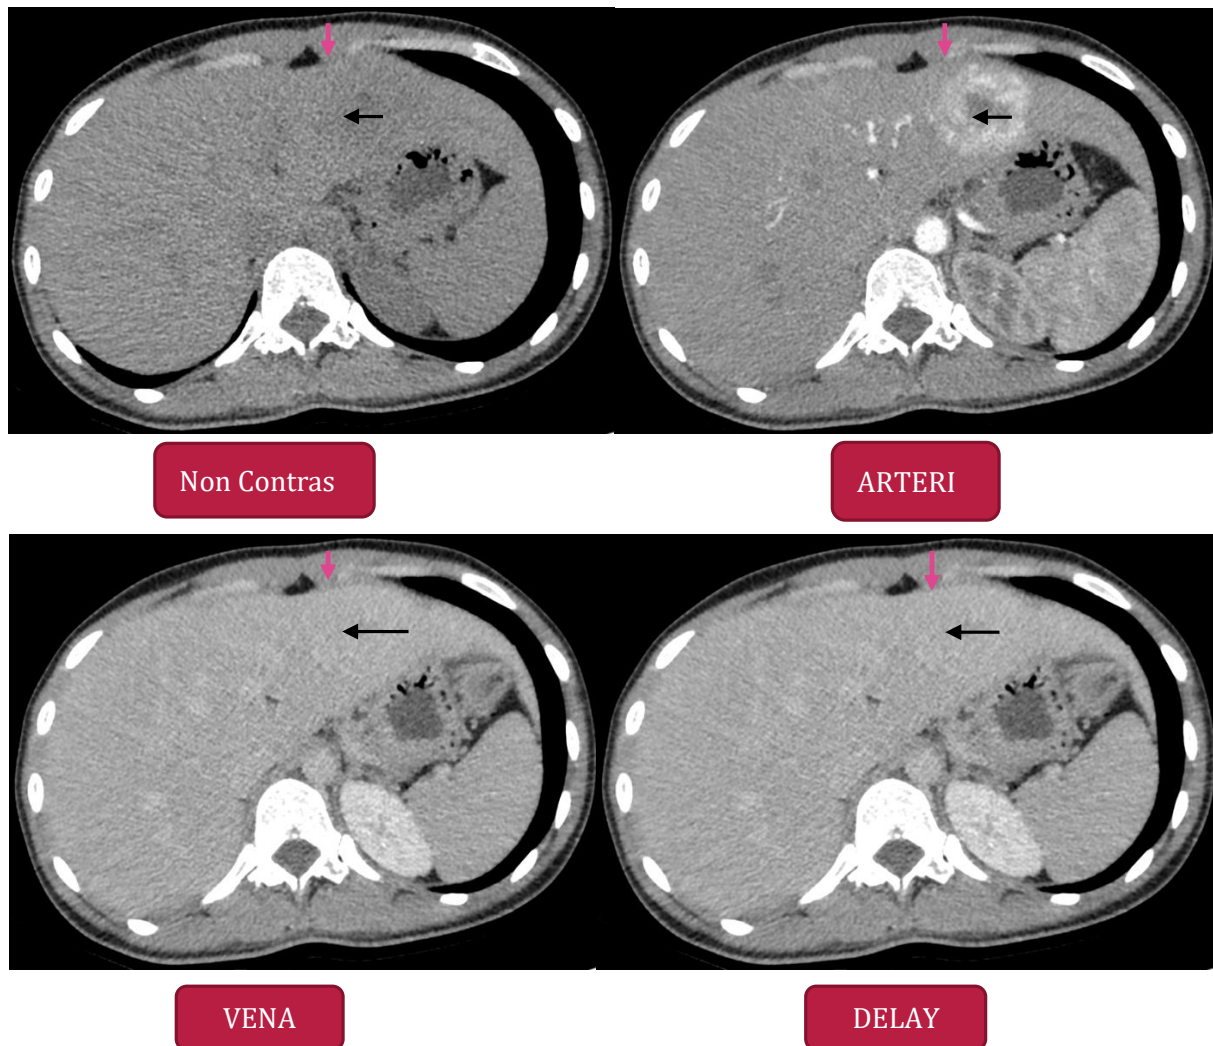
CT Scan Abdomen : A solid mass with partially indistinct margins and irregular edges in segment II of the left hepatic lobe (orange arrow). Following contrast administration, the lesion exhibits a rapid influx of contrast in the arterial phase, followed by a subtle yet persistent enhancement during the venous and delayed phases, distinguishing itself from the surrounding normal liver tissue. The lesion also shows central scarring (black arrow) that remains hypodense in all phases, including pre-contrast, arterial, venous, and delayed phases.
